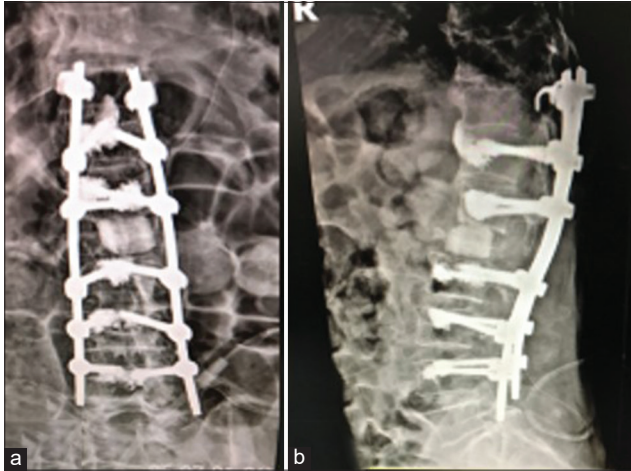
Postoperative lumbar X-ray, (a) anteroposterior radiograph shows proper placement of the allograft, note good coronal alignment, (b) lateral radiographs show correction of kyphosis and good sagittal alignment, note pedicle screws cement augmentation.
